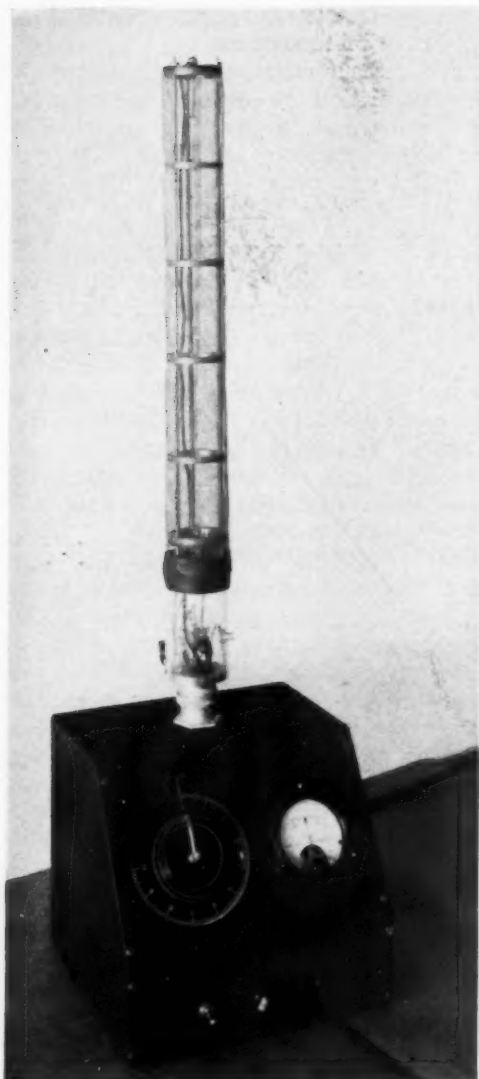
Special 800-c.c. ionization chamber used for measuring roentgen exposures of low intensity (0.01 to 0.20 milliroentgen).
